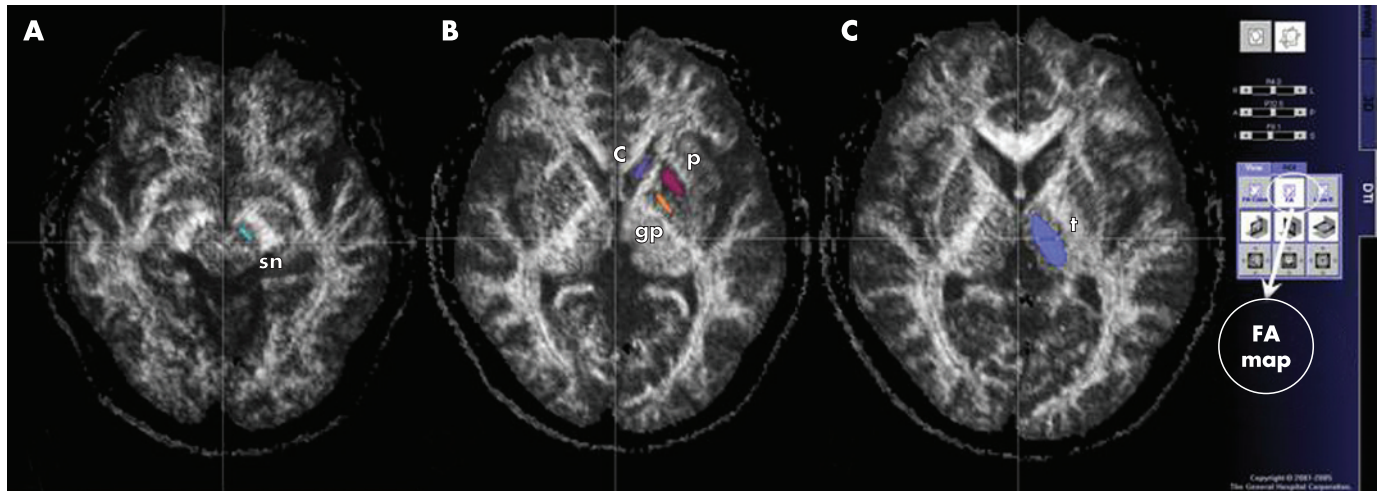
Regions of interest of gray matter structures: (A) substantia nigra (sn), (B) caudate (c), putamen (p), globus pallidus (gp) and (C) thalamus (t), drawn on axial diffusion tensor DTI MR images (4300/90) on the fractional anisotropy map. Regions of interests were analysed on both the right and left sides.
